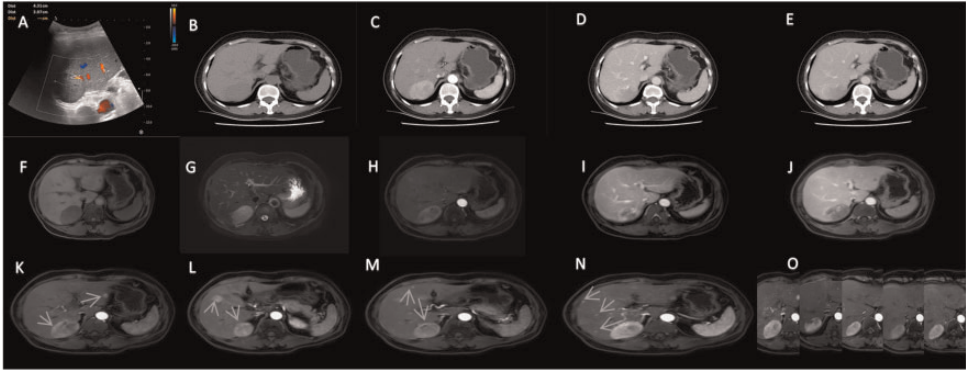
Representative images of various liver tumour manifestations in a 51-year-old female patient: (a) B-ultrasound scan at initial hospital admission showing a low-echoic mass in the liver; approximately 4.13 cm × 3.97 cm in size; (b) plain computed tomography (CT) scan at first hospital admission; (c), (d), and (e) contrast-enhanced CT images showing significantly increased density shadow in the liver parenchyma at early arterial phase, and decreased density shadows at the late portal phase and delayed phase, respectively; (f) and (g) first plain magnetic resonance imaging (MRI) scans showing multiple ovoid and rounded slightly longer T1-weighted and T2-weighted signal shadows in the liver parenchyma; (h), (i), and (j) MRI scans showing obvious uneven enhancement in the arterial phase, but decreased in venous (late portal) and transitional phases; (k), (l), (m), and (n) multiple liver tumours in the mid arterial phase during the first MRI enhanced scan; and (o) MRI images showing tumour (maximum) changes under the capsule of the right posterior lobe of the liver during first hospital admission (September 2020), re-examination and treatment (November 2020), and follow-up (December 2020, March 2021 and September 2021), respectively, showing little change.
